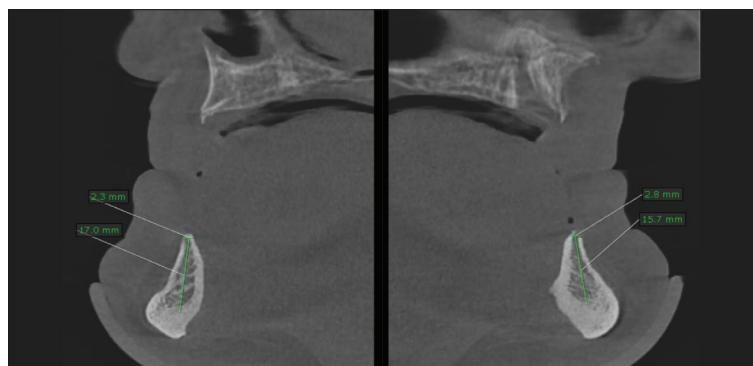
CBCT measurements of the width of alveolar bone
